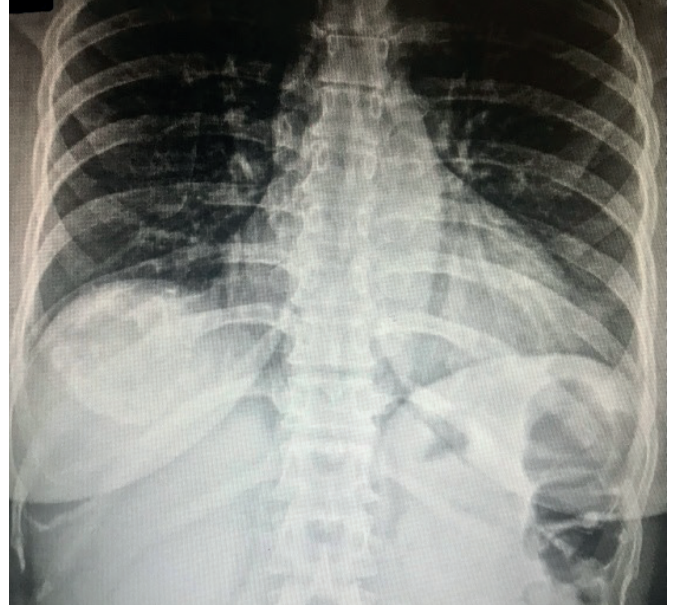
Radiograph of the dorsal spine.
